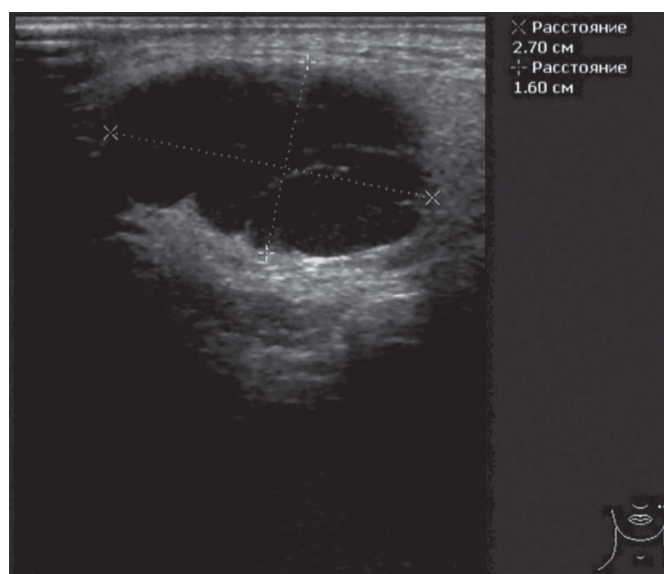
Sonographic image of a hypoechoic oval-shaped pleomorphic adenoma.
